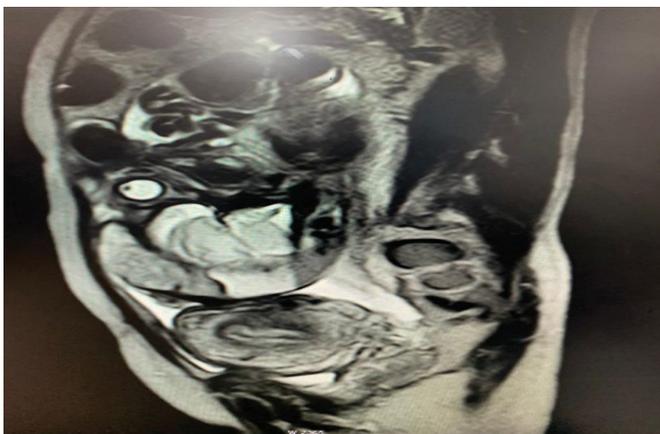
MRI T2 weighted image in saggital plane showing foetal head lying superior to uterus and empty endometrial cavity.
